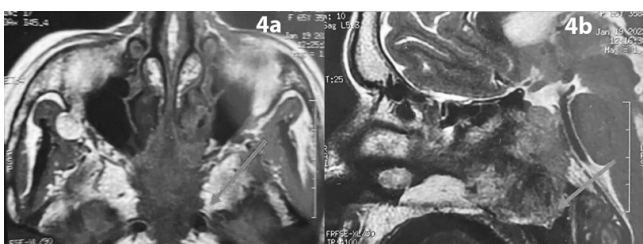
4a: Nasopharyngeal MRI in axial section, T2-weighted image: showing the unenhanced nasal tumor extending to the sphenoidal sinuses (arrow)
